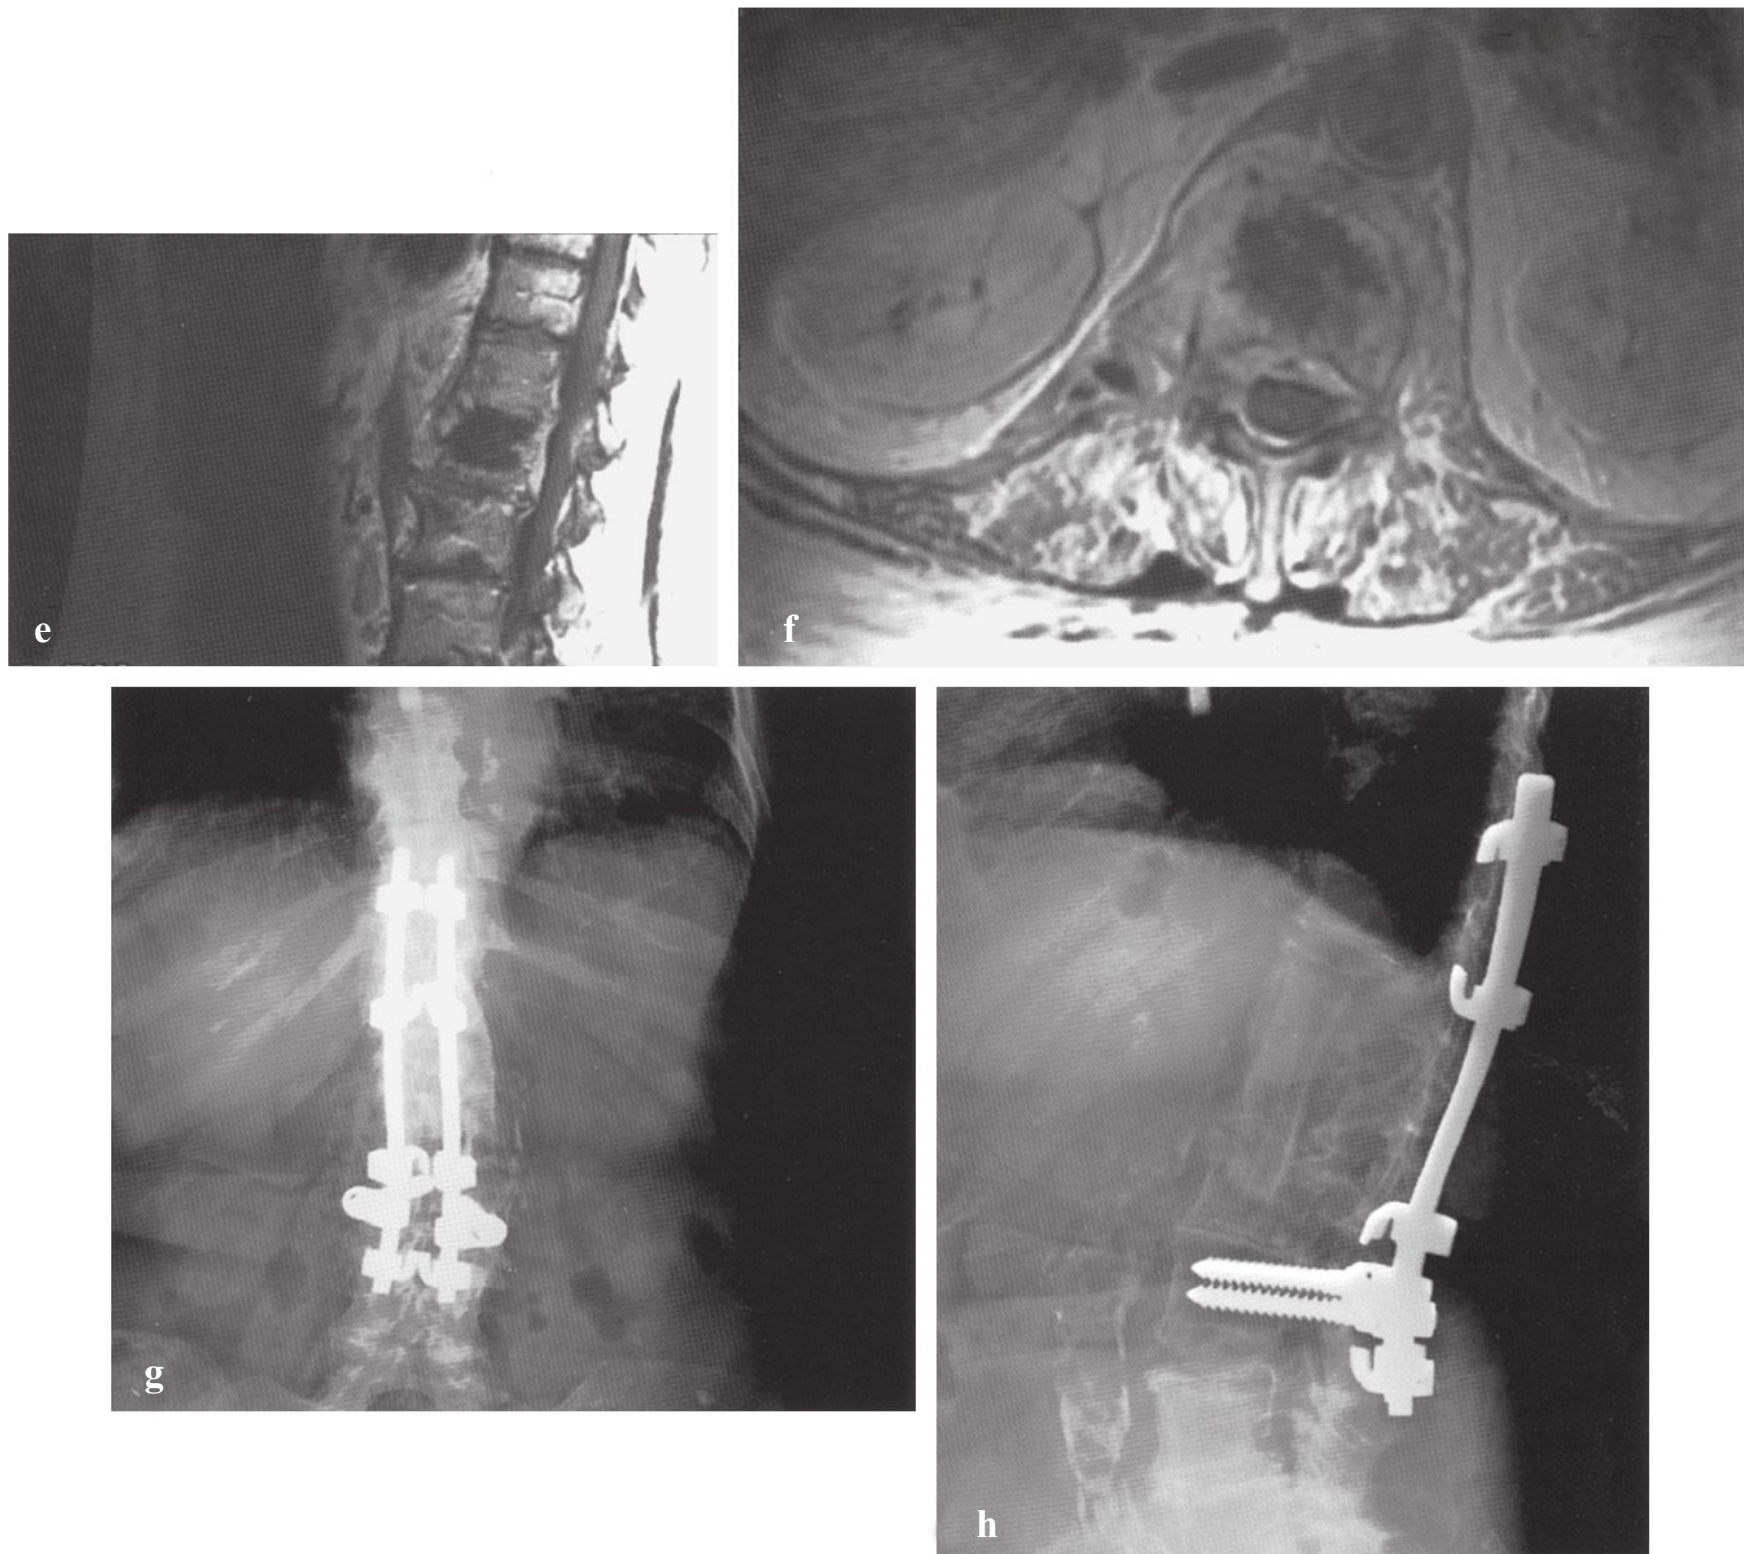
(Continued) A 76-year-old woman with rheumatoid arthritis and a T12–L1 diskitis/L1 osteomyelitis. Results of three needle biopsies were negative. (e) T1-weighted sagittal MRI sequence with gadolinium shows enhancement of the T12–L1 disk space and L1 vertebral body. There is a slight amount of enhancing tissue in the anterior epidural space without compression of the conus medullaris or cauda equina. (f) T1-weighted axial MRI sequence with gadolinium shows enhancement of the T12–L1 disk space. (g,h) Anteroposterior and lateral radiographs taken 6 months after surgery demonstrating incorporation of the bone graft anteriorly with solid fixation posteriorly.
